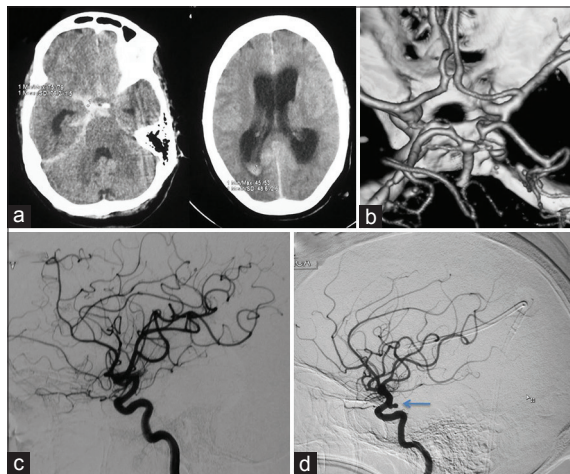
NCCT head showing bleed in anterior interhemispheric fissure, right sylvian fissure, suprasellar, prepontine and intrapeduncular cistern with intraventricular extension with moderate hydrocephalus (a); 3D-CTA brain appeared normal (b); Initial DSA brain failed to reveal any structural abnormality (c); Repeat DSA brain revealed a small bilobed posterior communicating artery aneurysm on right side (arrow) (d)
